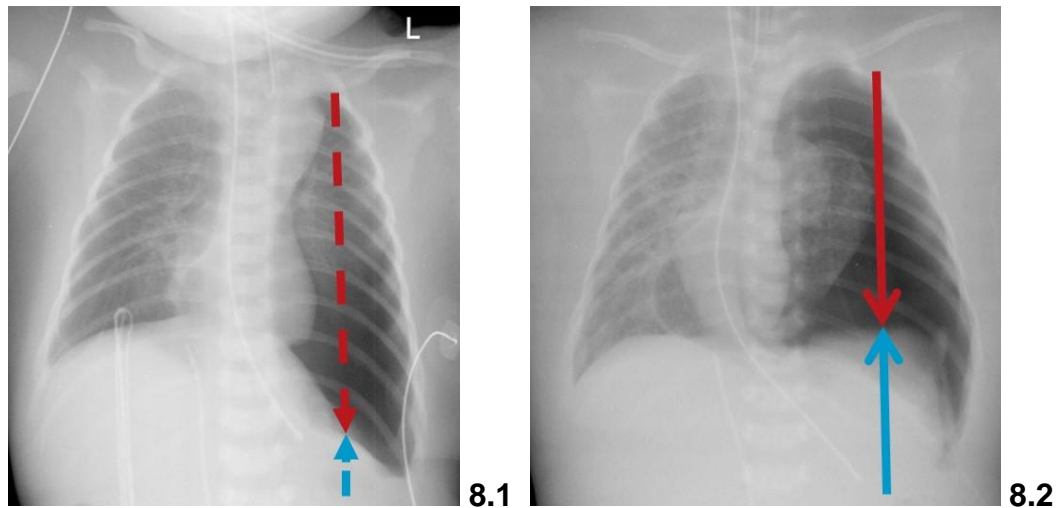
postoperative chest X-ray: intrathoracic volume indicated by red arrow, intraabdominal volume indicated by blue arrow; 8.1 after implantation of a plane patch; 8.2 after implantation of a cone-shaped patch (notice herniation of the left pleura to the right after repositioning a retrocardial spleen in a type D diaphragmatic defect)
